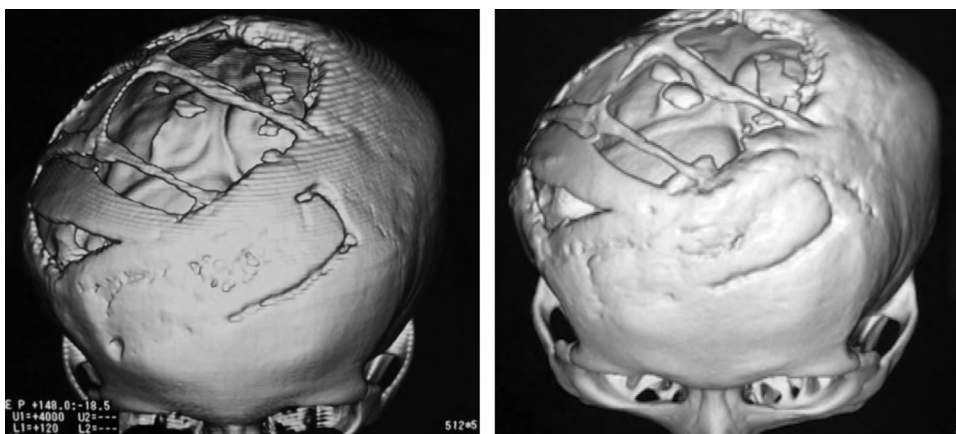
Catcher's mask cranioplasty in a 9-year-old boy. A, The CT image 10 days after the cranioplasty. B, The CT image 13 years after the cranioplasty at the age of 22 years.
